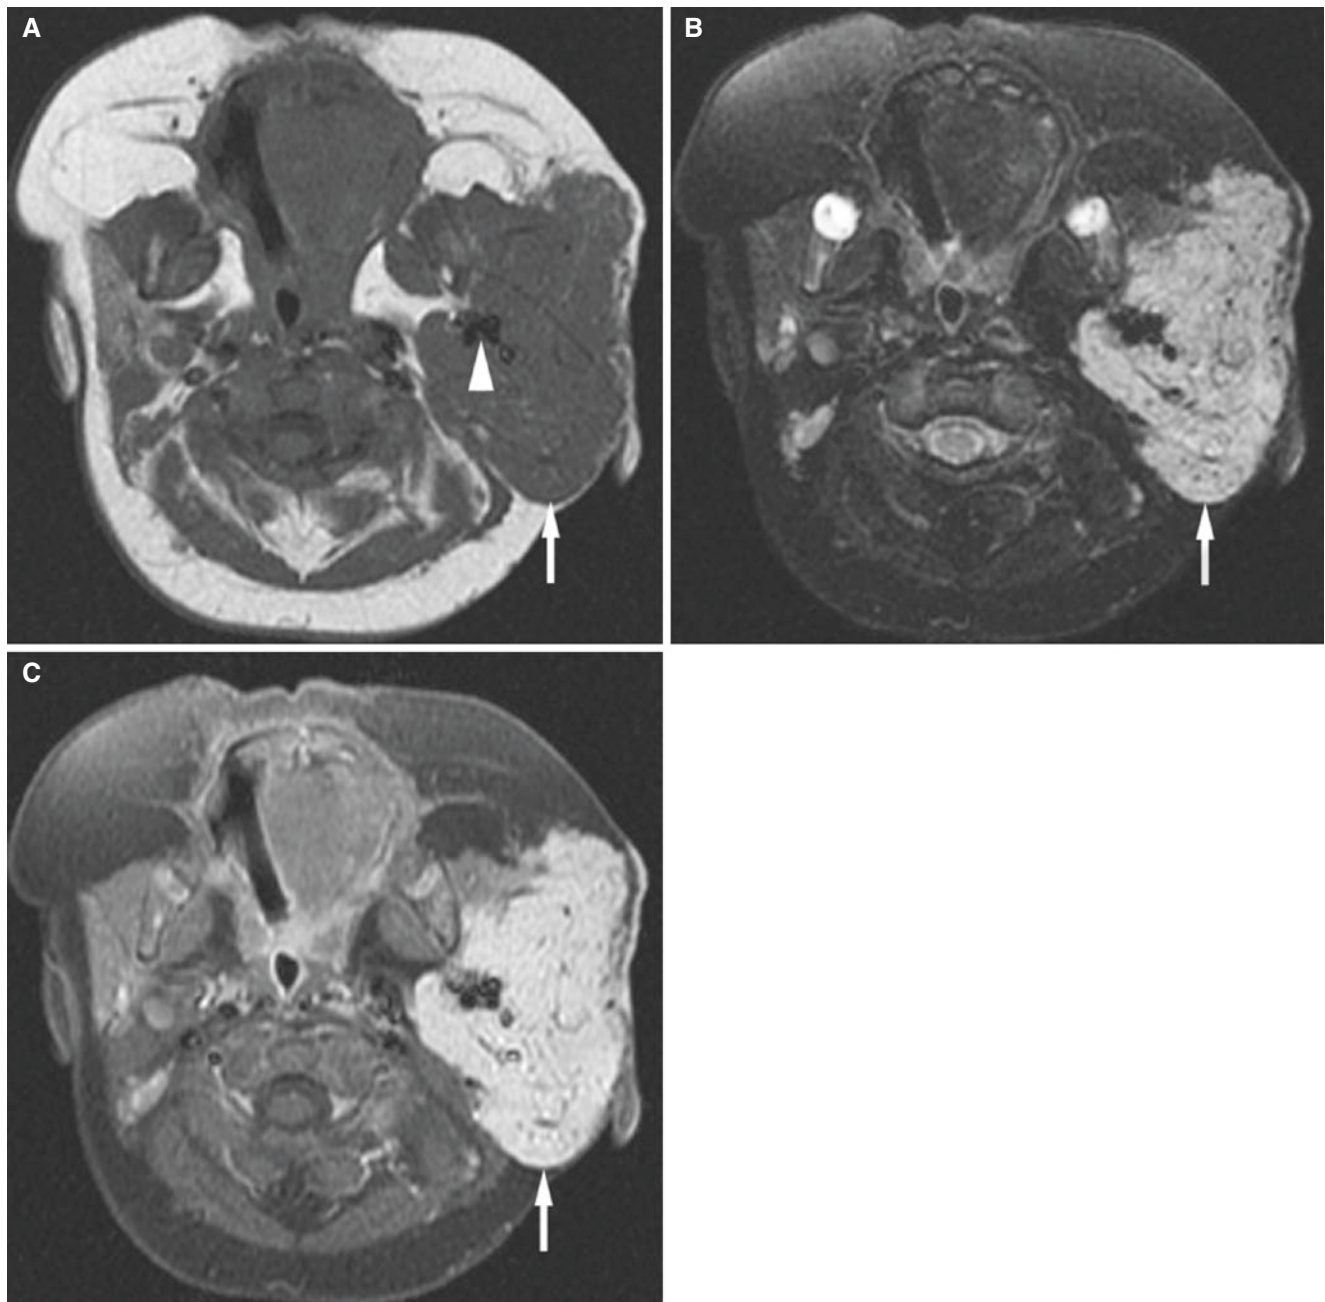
Parotid infantile hemangioma; 4-month-old male presenting with soft enlargement of the left parotid gland and a “birthmark” on the left cheek. (A) Axial T1-weighted MRI shows enlargement of the left parotid gland (*arrow*) with flow voids from large sinusoidal vessels
